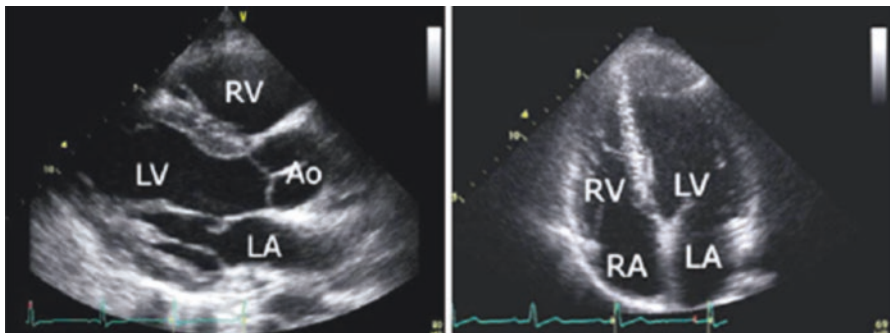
Common echocardiographic parasternal long-axis and apical sections which show the leaflets of the mitral and tricuspid valves. The sub-valvar apparatus can clearly be seen tethering the leaflets to the ventricular free wall. AO aorta, LA left atrium, LV left ventricle, RA right atrium, RV right ventricle
